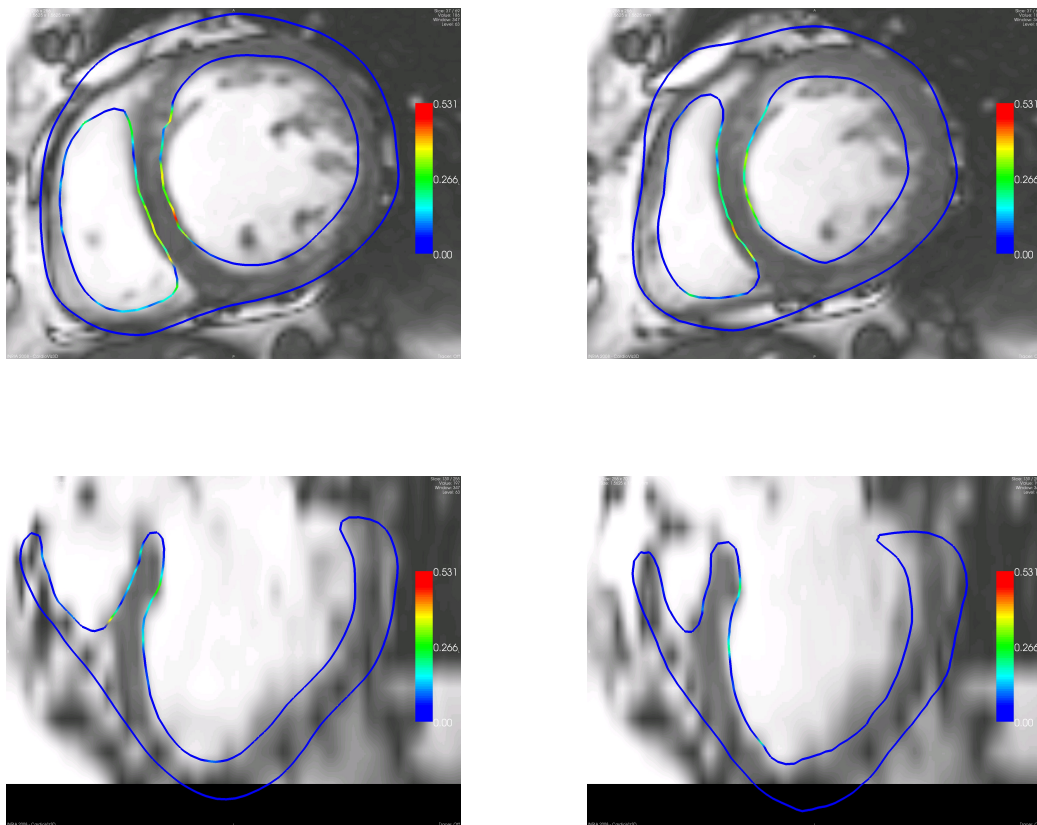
Results of the motion tracking: delineation of the estimated mesh surimposed with cine MRI at end-diastole (left column) and end-systole (right column). Colours encode the intensity of the image forces (blue: small, red: large).
